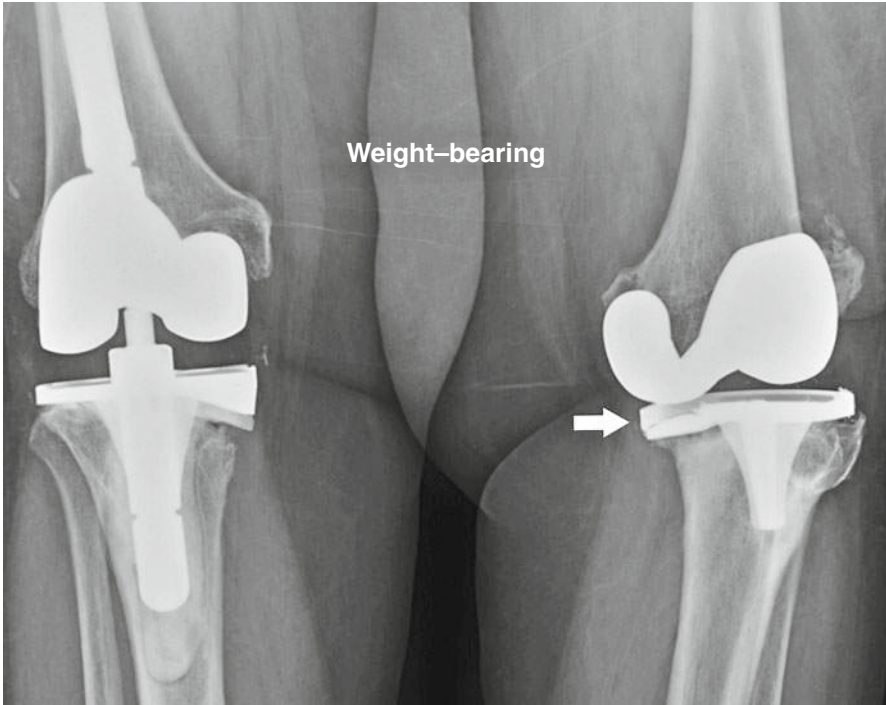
Hardware malposition. Knee X-ray anteroposterior standing view reveals left tibia varus, indicating failure of the medial tibial tray (*arrow*)
